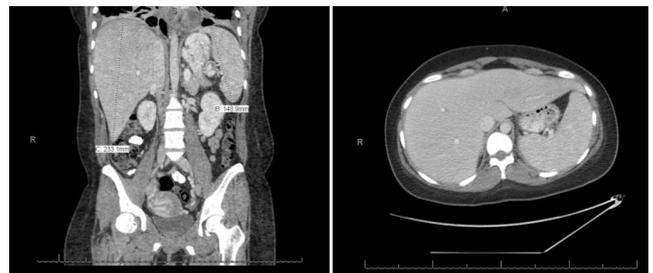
Initial CT of abdomen and pelvis demonstrating small bilateral pleural effusion and a very small pericardial effusion with no other cardiac abnormalities. There are enlargement of liver up to 23 cm and spleen 14.8 cm. There is a trace per hepatic and pelvic free fluid.
